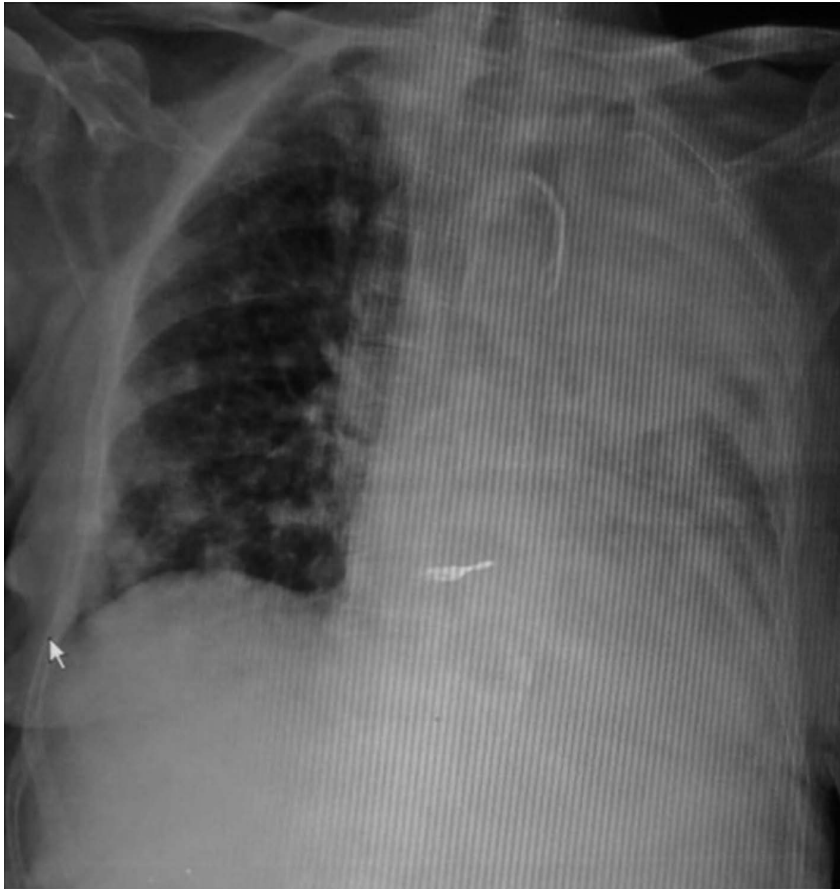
Chest X-Ray showed atelectasis of left lung originated by a bronchial obstruction, as well as right lung metastasis
